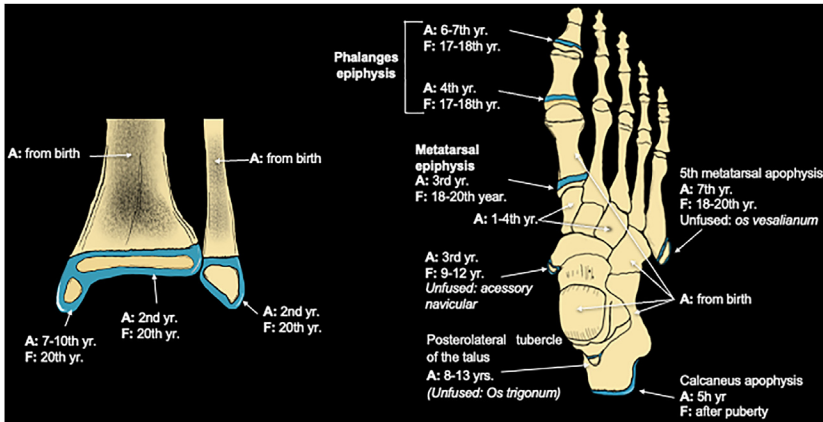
The important primary and SOC of the foot and ankle. Some unfused SOCs in the mature skeleton are accessory ossicles. A, age of radiographic appearance; F, age of radiographic fusion.
